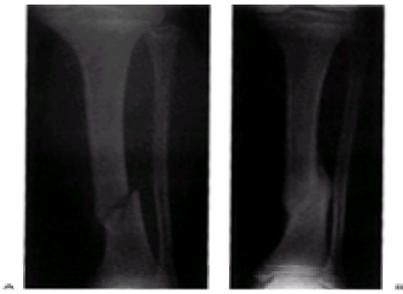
A: Spiral or oblique fracture of the tibia, without fibula fracture, is common in children. B: Radiograph at the time of union demonstrates satisfactory alignment with acceptable varus deformity.
